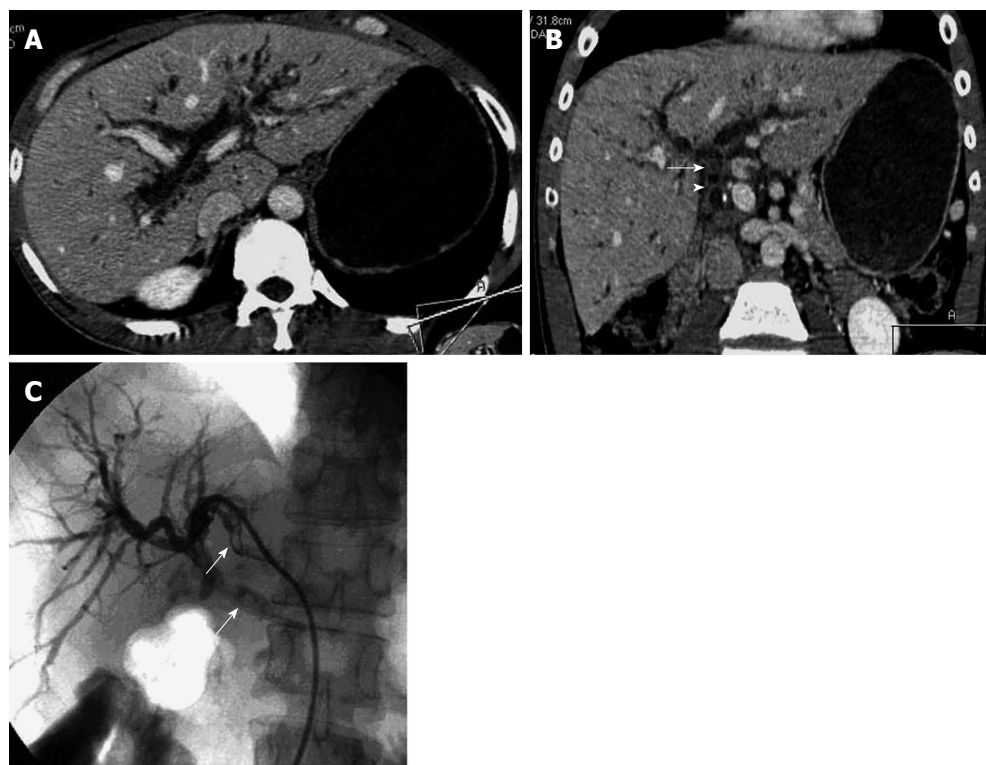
A 36-year-old man with obstructive jaundice due to anastomotic biliary strictures 5 mo after orthotopic liver transplantation. Computed tomography oblique reformat images (A, B) display biliary dilation at the intrahepatic and hepatic hilar bile ducts, biliary stone (arrow) and anastomotic strictures (arrowhead); C: Percutaneous transhepatic cholangiography demonstrates biliary dilation, anastomotic obstruction, and filling defect (arrow) in the common bile duct and the left hepatic duct which caused by biliary stone or sludge.
